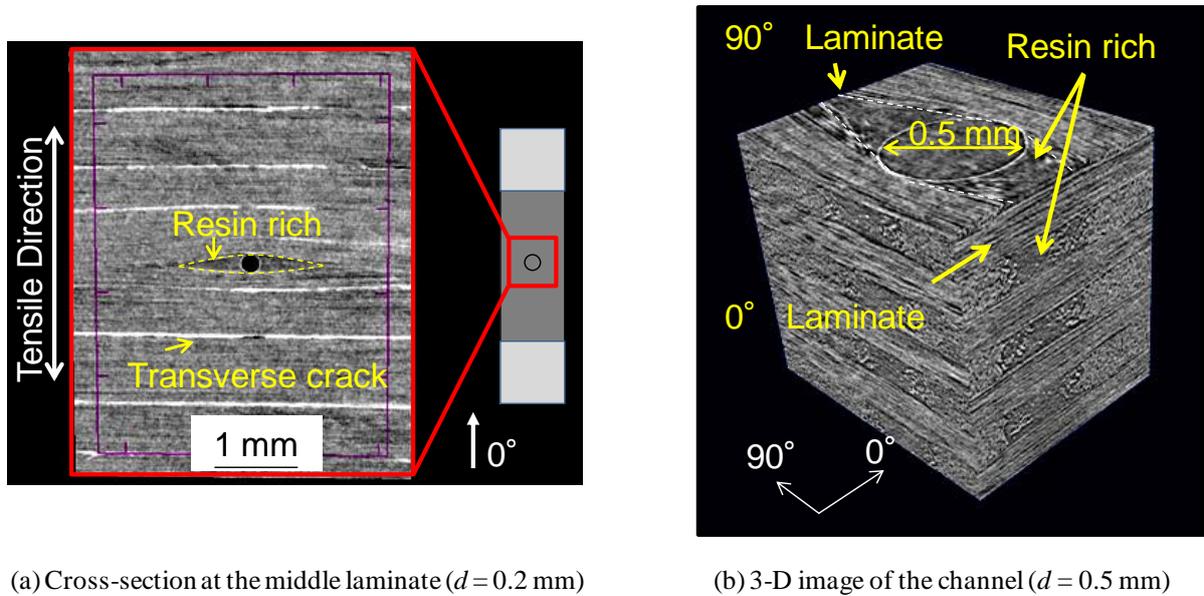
X-ray CT scanner observation around the channel.
